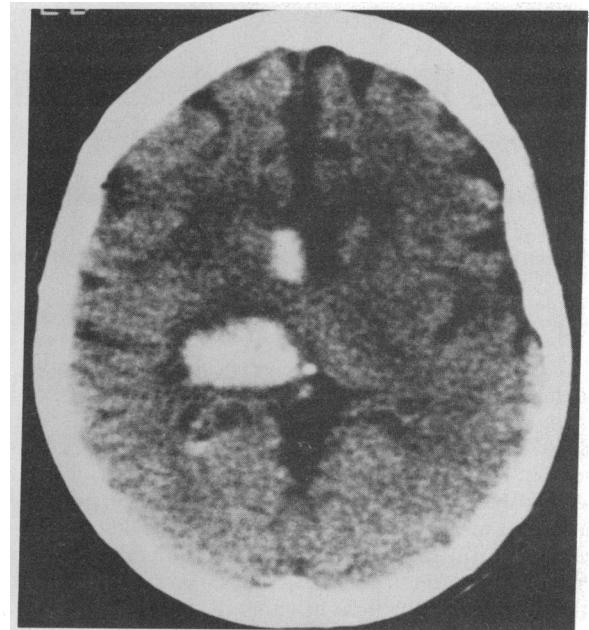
CT scan from patient VL at the time of her stroke showing a large hematoma (large white area) in the posterior right thalamus (small white area is blood in the lateral ventricle).
